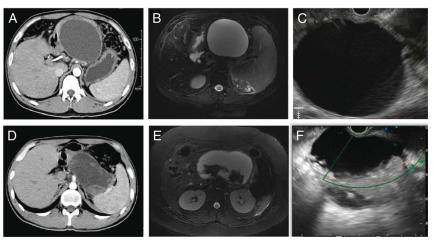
CT, MRI, and EUS images of typical PPC (A-C) and WON (D-F). CT: computed tomography; MRI, magnetic resonance imaging; PPC, pancreatic pseudocyst; WON: walled-off pancreatic necrosis.
